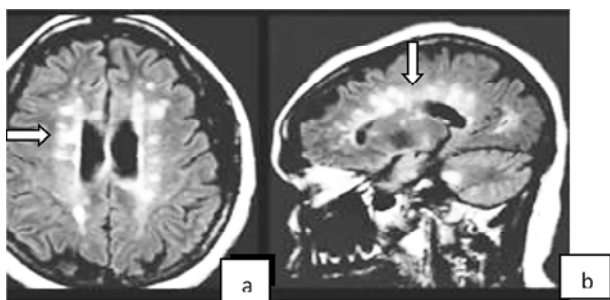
a & b. Axial and Coronal MR images showing multiple hyperintense lesions in periventricular white matter perpendicular to ventricular margins - Dawson's fingers. Involvement of corpus callosum seen in coronal picture
